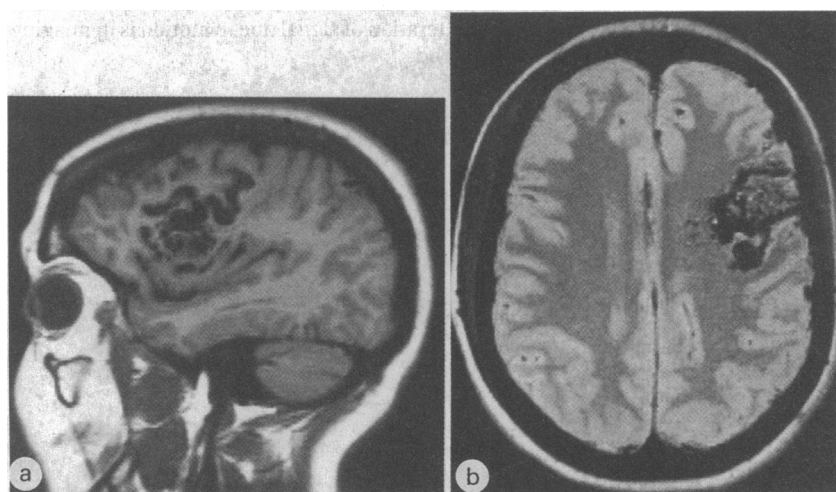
Magnetic resonance imaging of head showing large arteriovenous malformation. The large feeding and draining vessels are shown with great clarity by virtue of the signal void of flowing blood (a) T1 weighted parasagittal section; (b) axial section reflecting proton density
